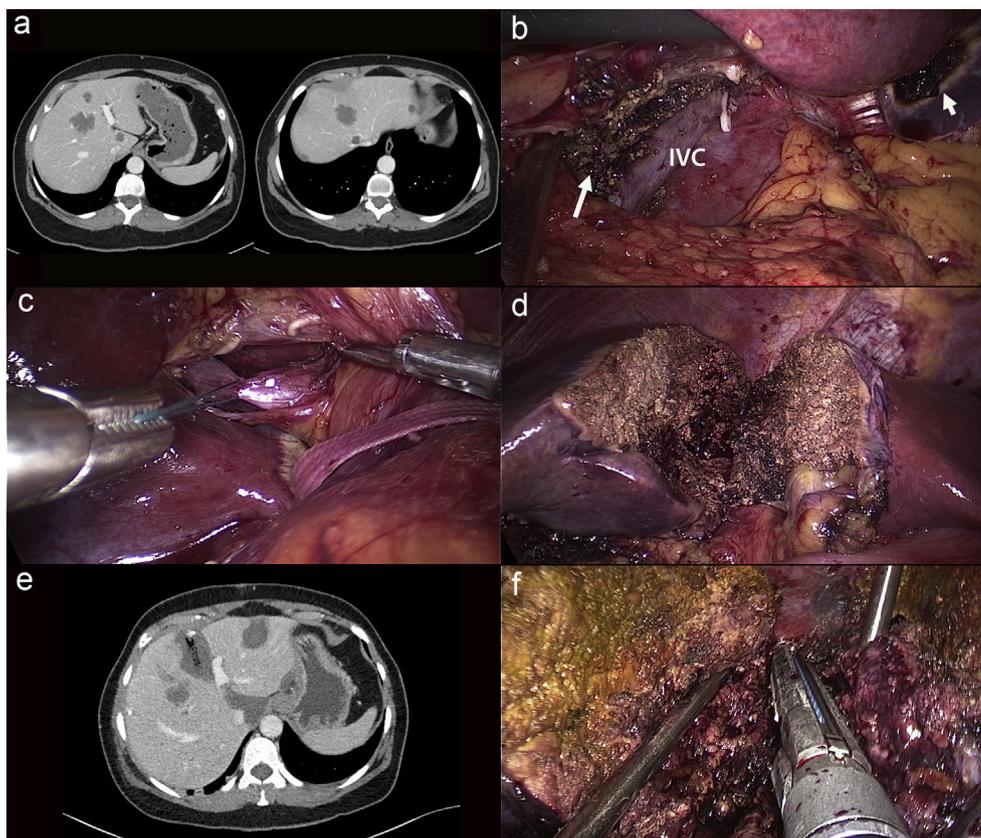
Main steps for laparoscopic ALPPS. a. Example of a patient with bilobar disease involving the right hepatic vein, segment 4, segment 1 and two additional lesions in segment 2 and 3 resulting in a very small FLR of 0.18. ALPPS is indicated in this scenario, but it may be performed laparoscopically as shown. b. Intraoperative photograph of the segment 1 resection (large arrow). IVC = inferior vena cava c. Portal vein occlusion is performed by ligation of the contralateral portal vein without mobilization of the right lobe. d. The liver is transected at the level of falciform ligament. e. CT scan between stages shows an adequate hypertrophy of the FLR to 115%. f. After the right lobe is mobilized, the right pedicle and the hepatic veins are exposed, and ALPPS is completed by taking the right and middle hepatic veins using the endostapler
